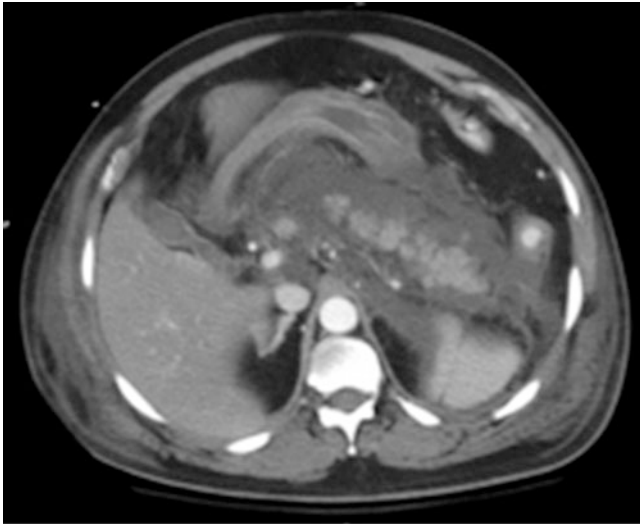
CT scan demonstrating retroperitoneal, peripancreatic fluid, and enhancement of distal pancreas
